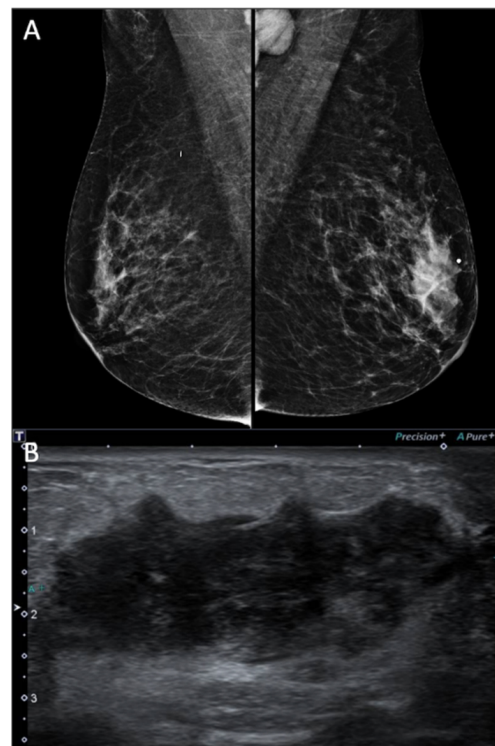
Bilateral mammography on mediolateral oblique (MLO) view (A) showed an irregular hyperdense mass in the upper quadrants of the left breast, near the metallic marker in the left breast lump, and left axillary lymph node enlargement. Ultrasound (B) revealed an irregular hypoechoic mass in the left breast with posterior acoustic enhancement.
